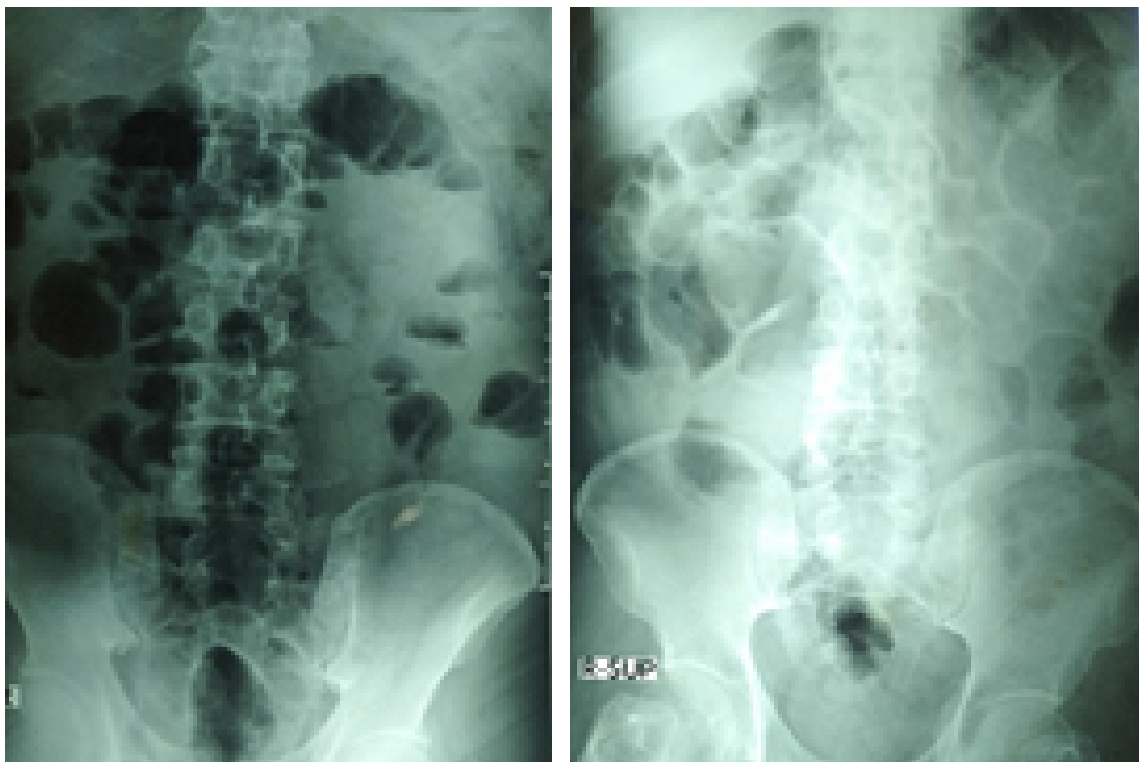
Supine X-ray of the abdomen showing impacted stools without air-fluid levels supportive of hypercalcaemia
